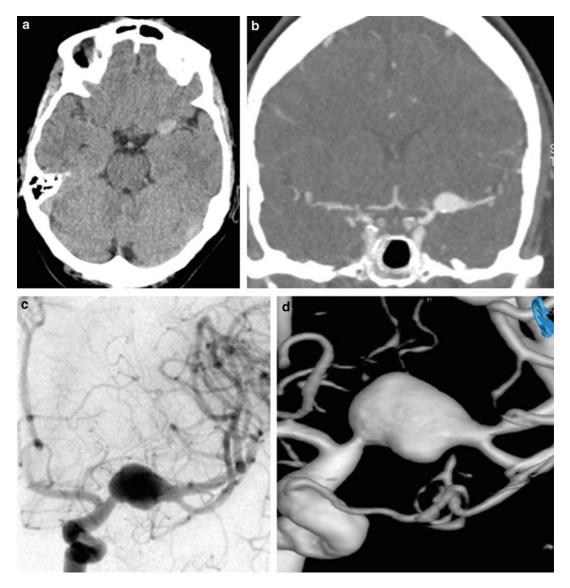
Diagnostic imaging in a fusiform aneurysm of the left M1 segment. NCCT (axial view (a)) ruled out an SAH and revealed as an incidental finding a hyperdense oval lesion, strongly suspicious of an aneurysm of the left MCA. CTA (coronal view (b)) confirmed the diagnosis
